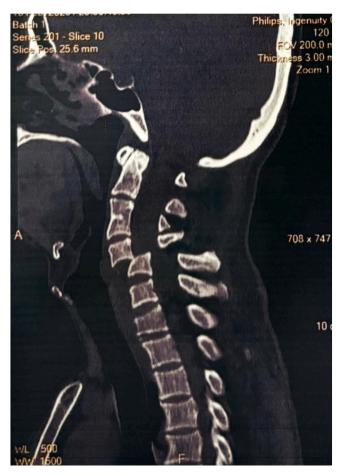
Lateral plain x-ray of the cervical before surgery, shows dislocation of 5–6 cervical vertebrae.
